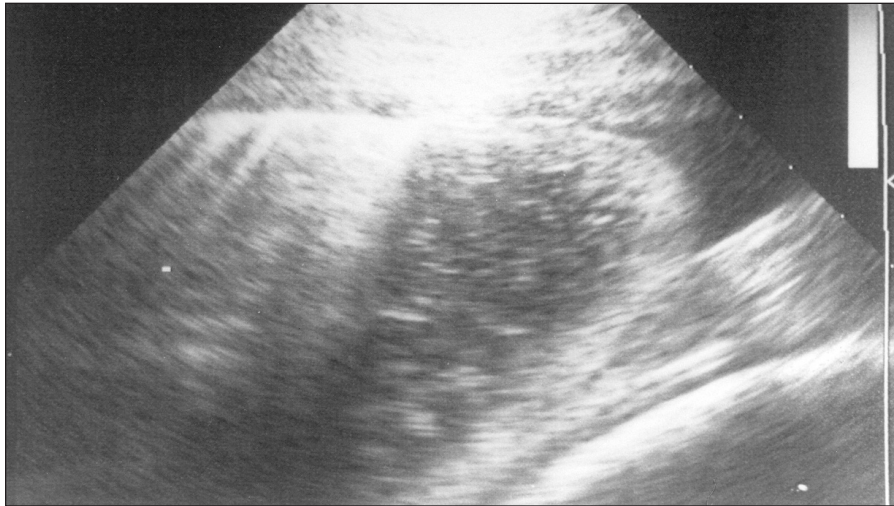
Long-axis sonogram of the left side of the thorax of a 5-year-old Thoroughbred gelding evaluated because of muffled lung sounds and sudden onset of signs of abdominal pain. Dorsal is to the left, ventral is to the right.
